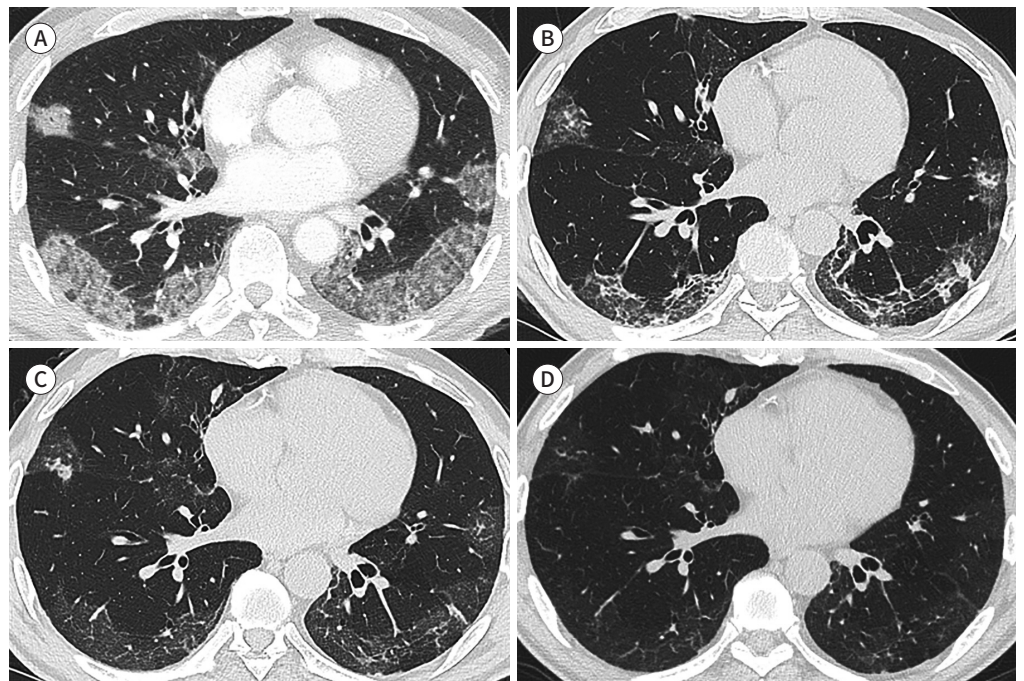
Serial changes of CT findings in a 64-year-old female patient with COVID-19 pneumonia.
